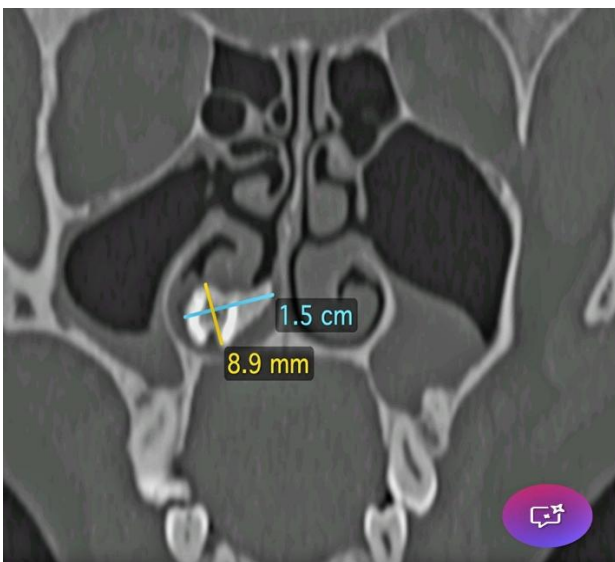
CT scan para nasal sinus showing radio opaque tooth like structure originates from inferior turbinate.
